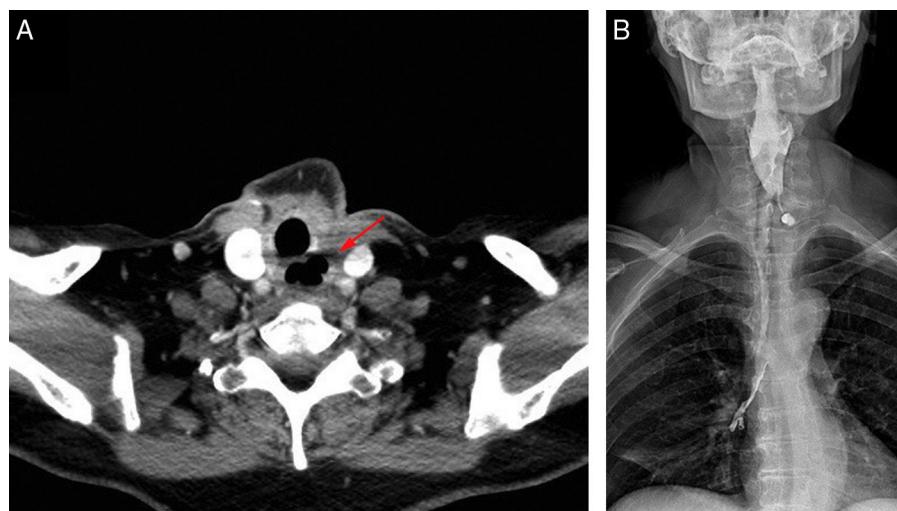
(A) Computed tomography: air space corresponding with a cervical oesophageal defect (arrow). (B) Oesophageal videofluoroscopic swallow study showing contrast extravasation through the cervical oesophageal fistula, with no passage to the distal oesophagus, and aspiration of the contrast to both main bronchi.
